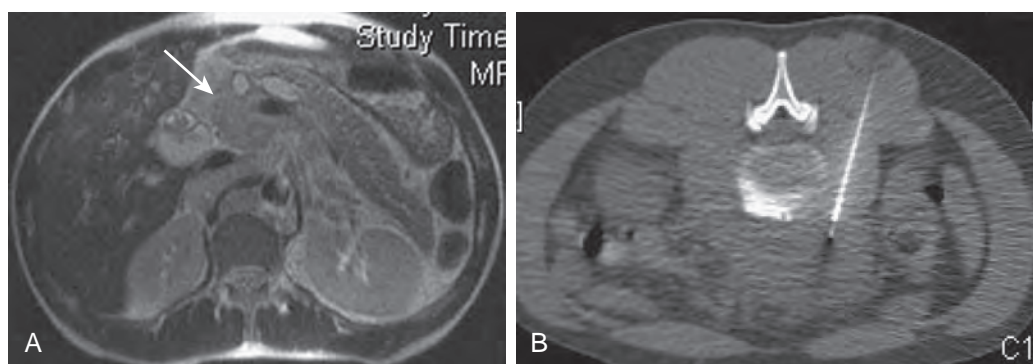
Percutaneous biopsy of pancreatic lymphoma. A. Axial T2-weighted MR image shows hyperintense mass (arrow) in the head of the pancreas with associated ductal dilation. Also note extensive portocaval and retrocaval lymphadenopathy. B. Axial noncontrast CT image (patient in prone position) shows needle sampling (25 gauge through 20 gauge) of pancreatic mass by coaxial technique and a posterior approach; cytology revealed pancreatic lymphoma.
